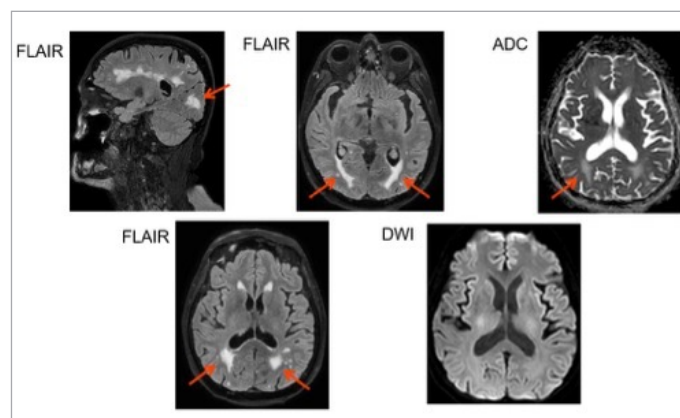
PRES syndrome MRI.
